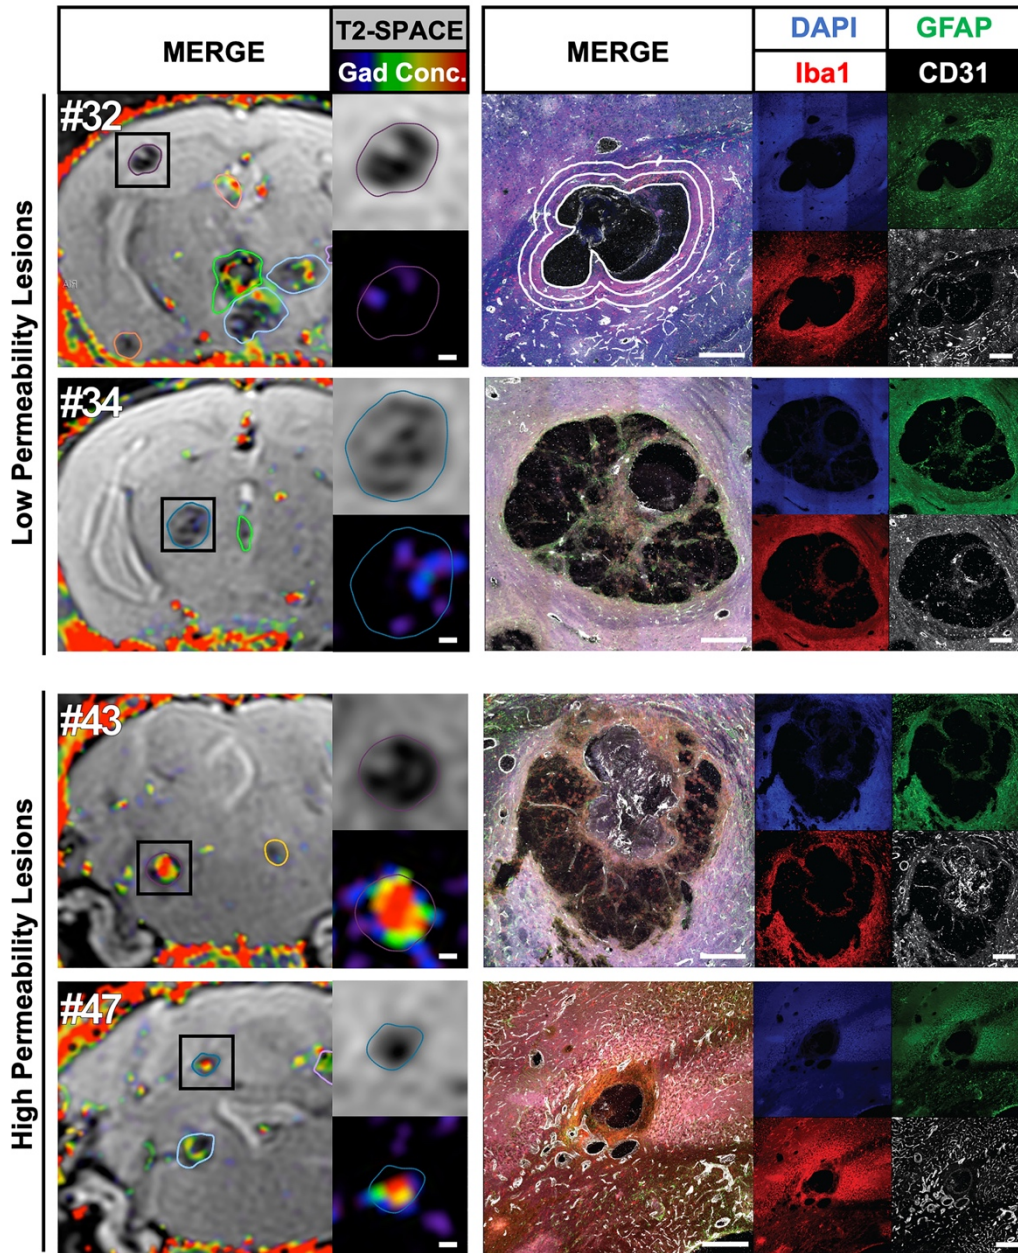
The MRI and histochemical signatures of CCM lesions with low and high permeability. Two lesions with the lowest permeability (#32 in the subcortical corpus callosum, MultiHance concentration 41 ng/mm^3 ; and #34 in the thalamus, MultiHance concentration 58.9 ng/mm^3 ; see Table S1) are shown on top. Two lesions with the highest permeability (#43 in the brainstem, MultiHance concentration 185.8 ng/mm^3 ; and #47 in the cerebellum, MultiHance concentration 250.5 ng/mm^3 ; see Table S1 for an overview of measurements) are shown at the bottom. MRI insets show T2-SPACE images and gadolinium concentration maps of each lesion in detail. Matching IHC images of each DAPI, GFAP, Iba1 and CD31 channels are shown on the right, next to the 4-channel overlay. Large, highly permeable lesions typically contain numerous CD31-positive endothelial cells. All scale bars are $200 \mu\text{m}$. White lines drawn on merged IHC image for
